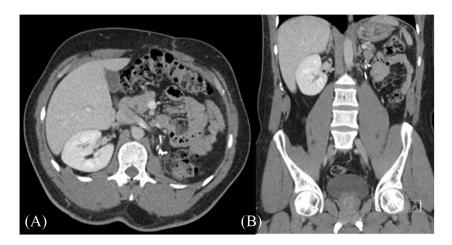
Postoperative images obtained 6 months after the second surgery, axial (A) and coronal (B) enhanced CT scan of the abdomen and pelvic showed no signs of recurrence with clear peri-renal bed.
